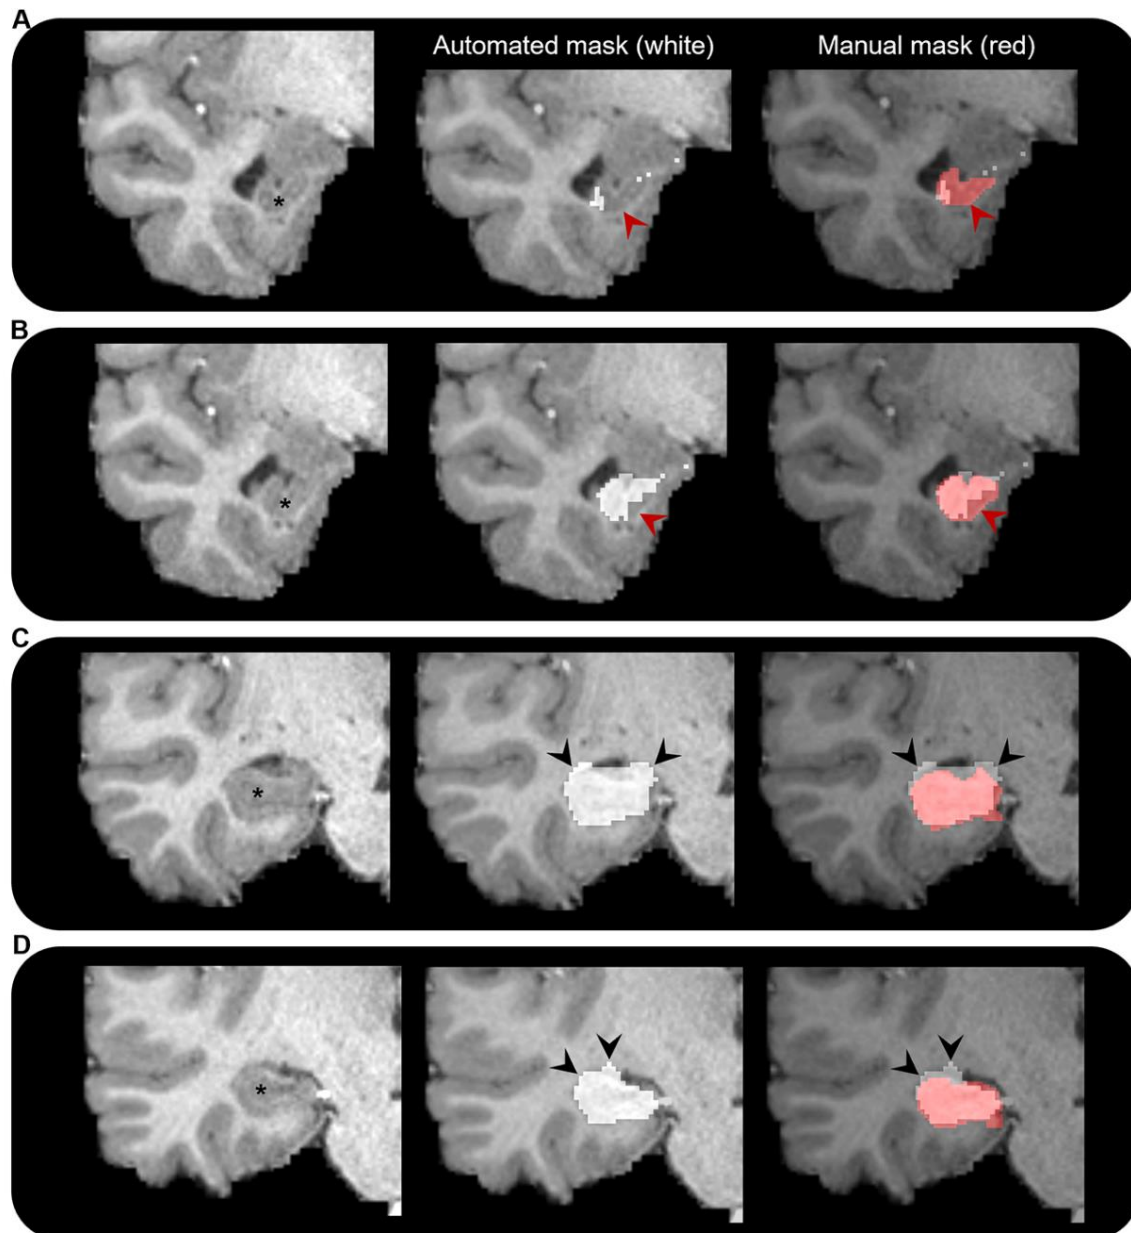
Comparison of automated and manual hippocampus segmentations. Representative examples of the automated hippocampus mask derived from the HCPMMP and the manually segmented hippocampus mask. We display examples from anterior (a) to posterior (d) portions of the hippocampal head. In each panel, we present a coronal slice of the T1-weighted image focussed on the right temporal lobe for a single participant (left; hippocampus indicated by *), the same image overlaid with the automated hippocampus mask derived from the HCPMMP (middle; white) and the same image overlaid with both the automated HCPMMP hippocampus mask (right; white) and the manually segmented hippocampus mask (transparent red). Note, in the anterior most slices (a and b) the automated mask does not cover the entire extent of the hippocampus (indicated by red arrows) and in more posterior slices (c and d) the automated mask often overextends across the lateral ventricle superior to the hippocampus and into the adjacent white matter (indicated by black arrows). Streamlines making contact with these erroneous portions of the automated hippocampus mask may lead to results that are biologically implausible.
